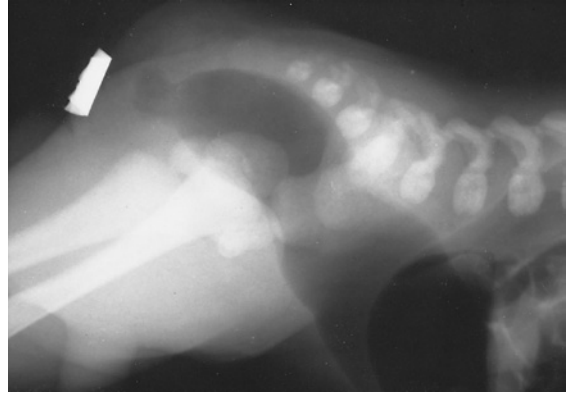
Prone, cross-table lateral radiograph in a baby with no fistula, but an imperforate anal membrane, with gas-filled bowel extending nearly to the marker on the skin.
